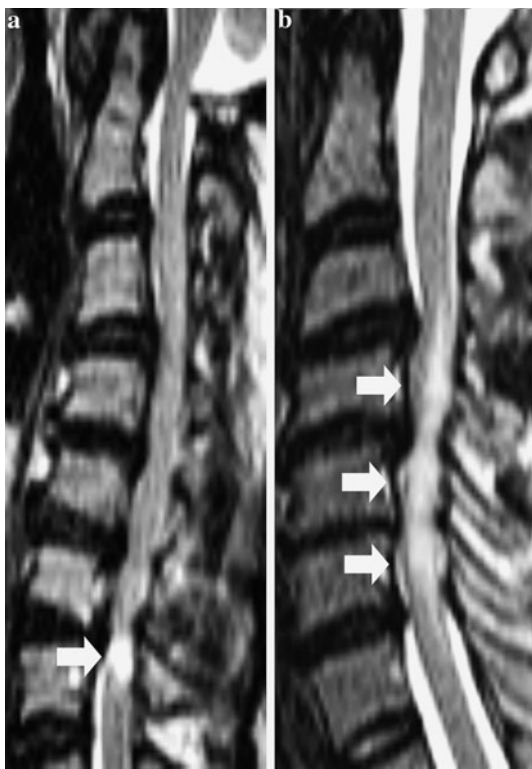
T2-weighted (T2W) sagittal MR images showing the L2 classification of T2W increased signal intensity (ISI). a Type 1, focal T2W ISI (arrow). b Type 2, multisegmental T2W ISI (arrows)
